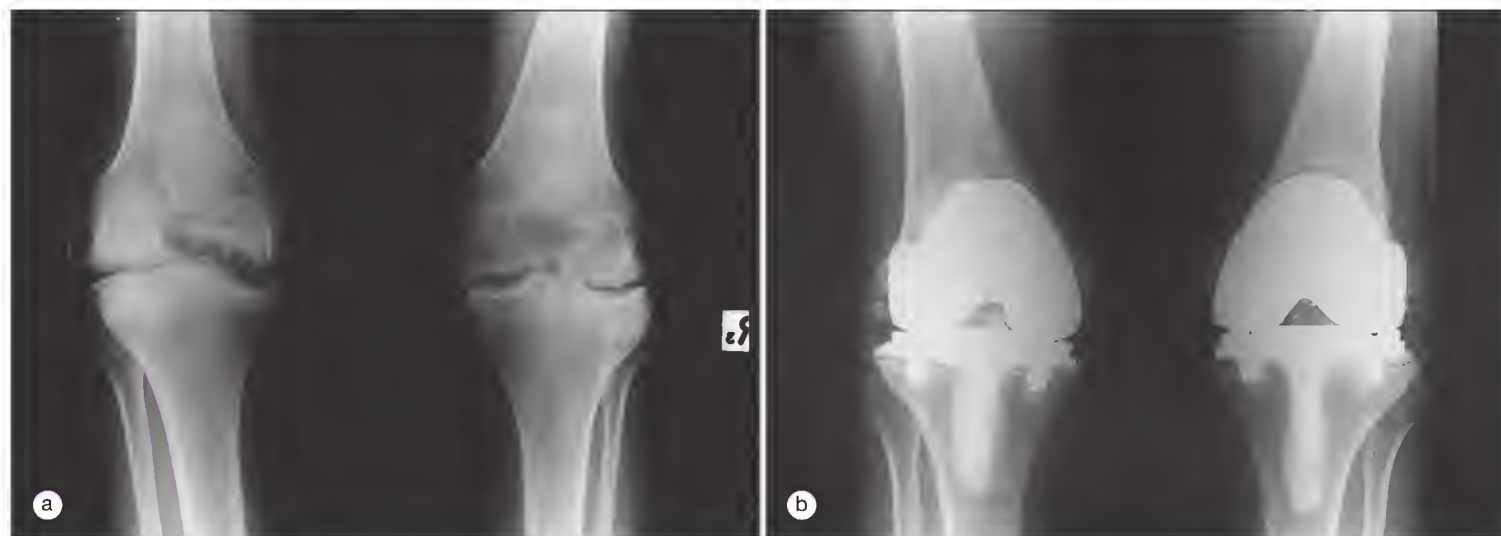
Chronic hemophilic arthropathy. Radiographs show chronic hemophilic arthropathy and joint destruction of the knee (a) and the consequent arthroplasties (b).
